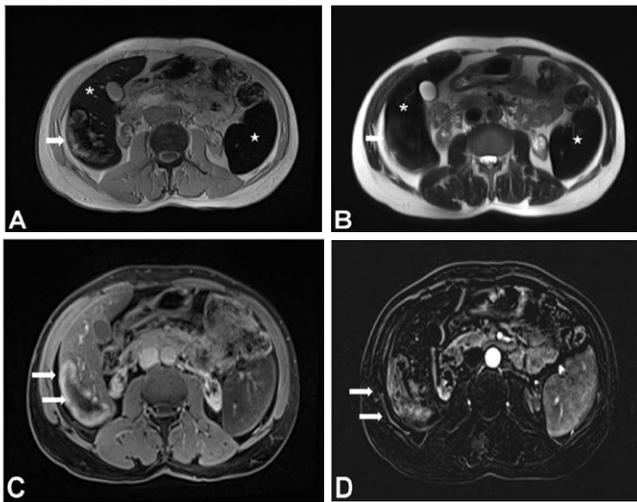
The first MRI study shows extremely hypointense signal intensity in the liver (asterix) and spleen (star) on T1 (A) and T2WI (B). MRI also demonstrated a large solid lesion in liver segment VI (arrow) with a peripheral high signal intensity on T1 (A) and T2WI (B). T1 with contrast image (C) and subtraction image (D) show heterogeneous peripheral enhancement after contrast administration.
